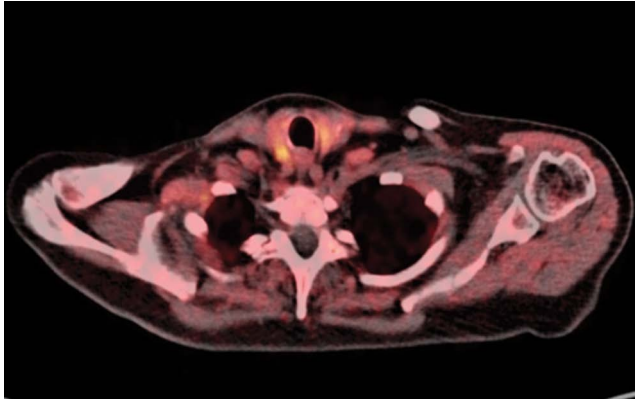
[^{18}F]FCH PET/CT showed increased uptake in the parathyroid gland localized behind the right thyroid lobe
